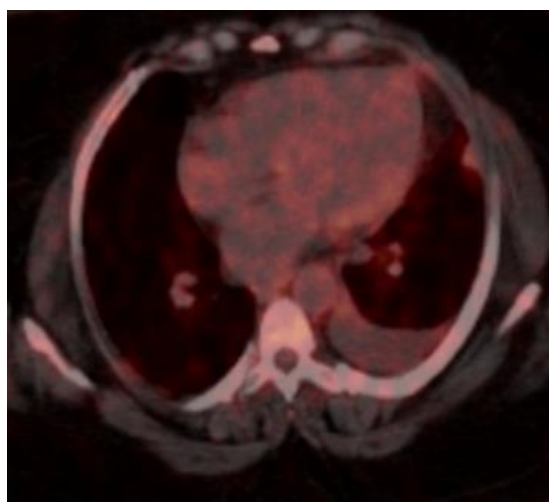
Left pleural effusion identified on PET-CT performed to rule out malignancy (SUVmax, 3.5).
